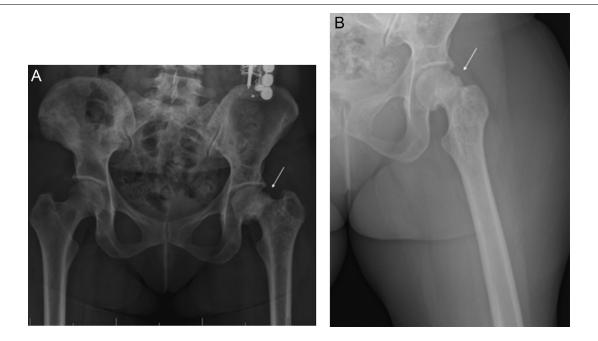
Radiograph AP pelvis (A) and lateral (B) left femur obtained in 2019 showing extensive metastatic disease of the bony pelvis with minimally displaced pathologic fracture (arrow) of the sub capital region of the left femoral neck.
